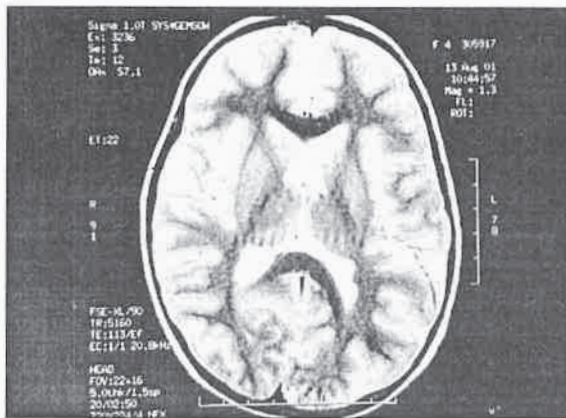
Axial T2-weighted image obtained 3 months later reveals complete regression of the lesions.
